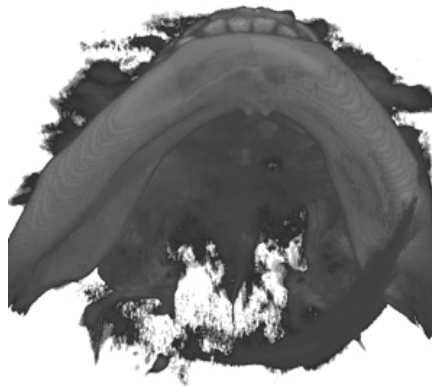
Bottom-up of a raw CBCT volume.
